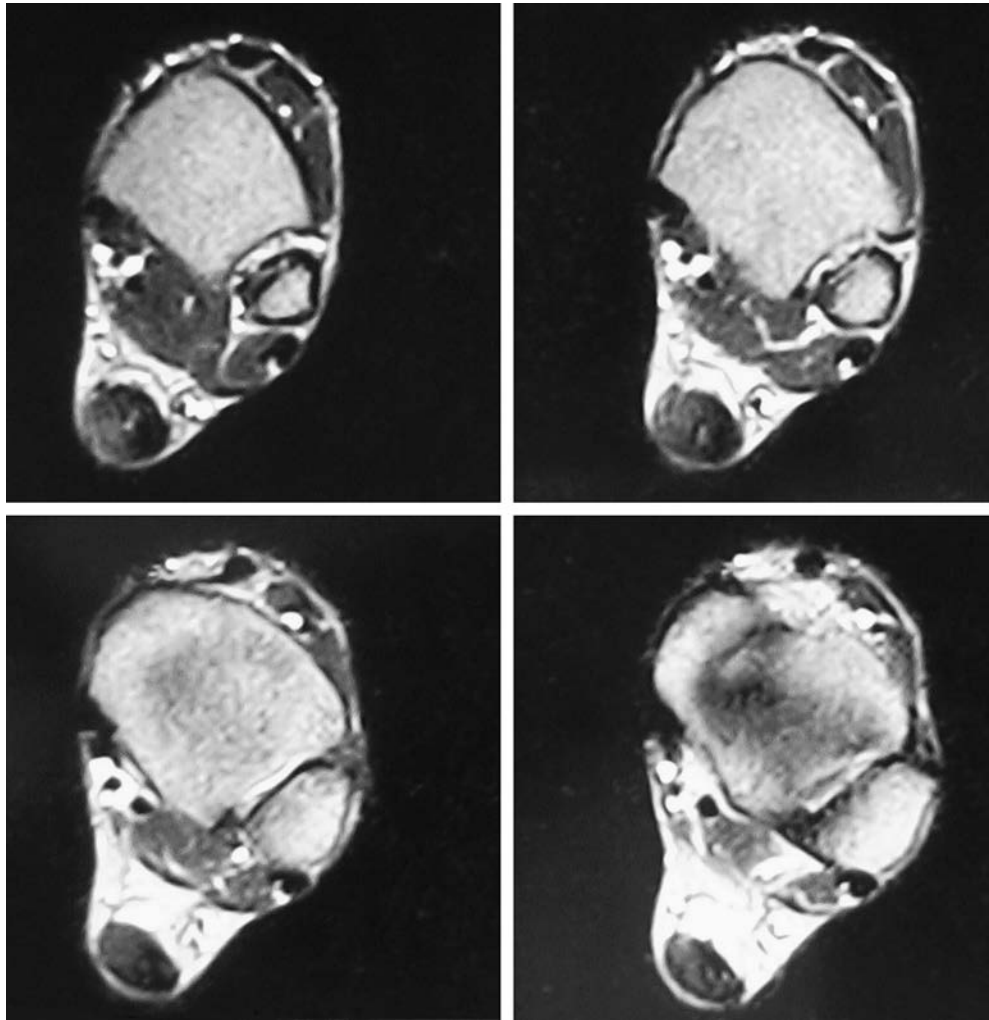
Magnetic resonance imaging cross section of the Achilles tendon demonstrating more than 80% tendon involvement. This would indicate the need for tendon augmentation or transfer following debridement.
